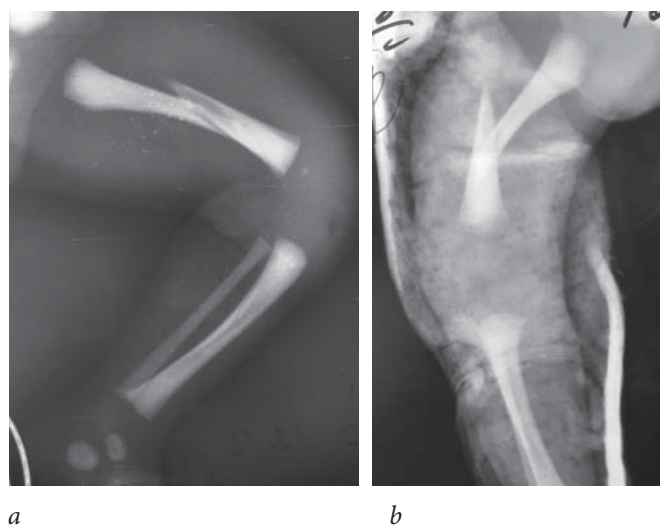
X-rays of the right femur of the newborn patient, K. A displaced spiral fracture of the femoral bone (*a*). Condition after closed manual reposition and immobilization with plaster cast (*b*)
